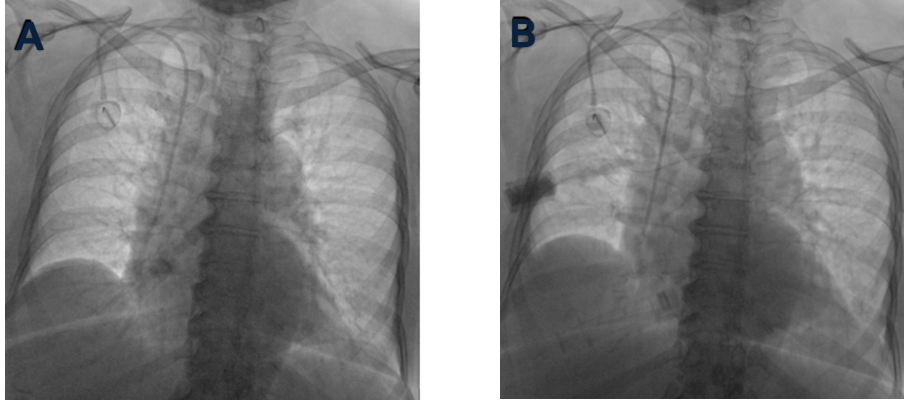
A. A chest x-ray shows normal curvature of the catheter. B. An injection of contrast demonstrates no evidence of leakage or extravasation.
